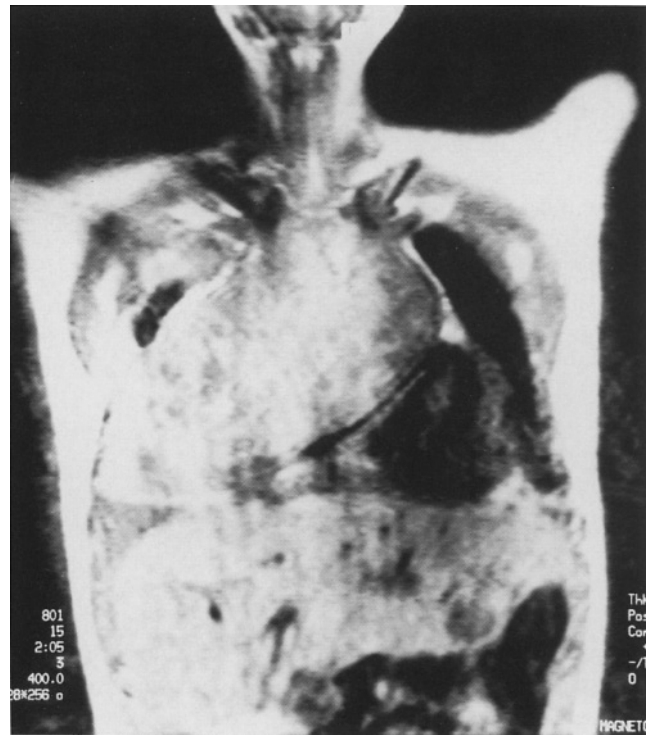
MRI of the thorax. Motion artifacts are seen. A huge intrathoracic mass is visible extending to the right lateral chest wall and opacifying most of the right hemithorax.
